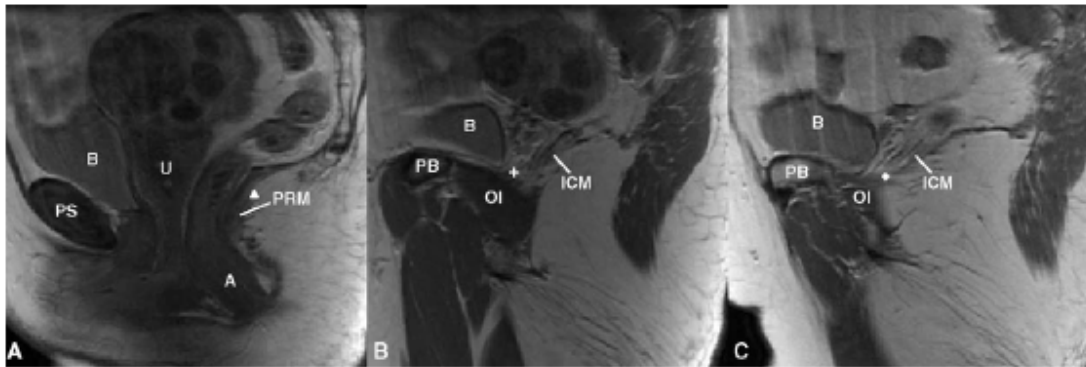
Separating the pubic portion of levator ani from the iliococcygeus portion on MR scans. a): identification of the middle point (triangle) on the mid-sagittal MR image; b & c): identification of the two lateral points on MR image (cross and diamond). The following structures were identified in MR image to help for orientation. PS: pubic symphysis; PB:pubic bone; B: bladder; A: anus; OI: oburator internus; U:uterus (with fibroids); PRIM: puborectalis muscle. ICM: iliococcygeus muscle
